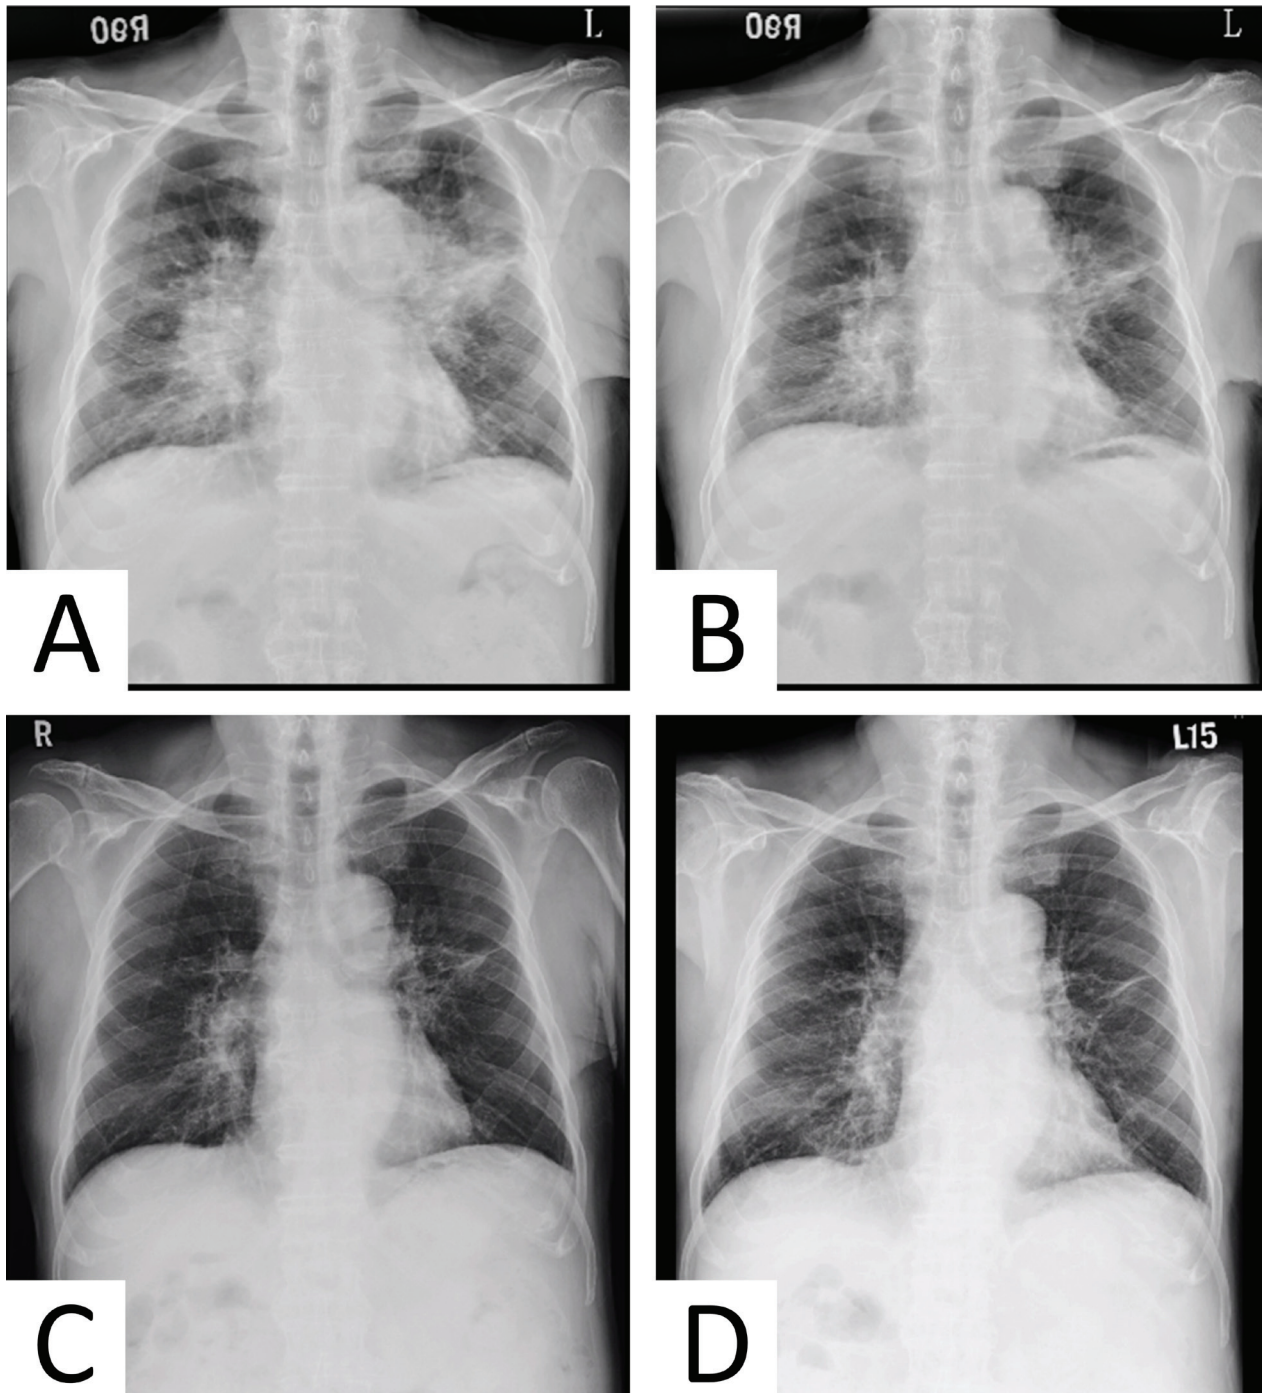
Serial chest radiographs of this 78-year-old man showed a rapid response to corticosteroid therapy, with long-lasting effects. (A) On day 1, a chest radiograph just prior to the corticosteroid therapy showed patchy consolidations with a central distribution in the bilateral hilar area. (B) After completion of a 7-day course of intravenous methylprednisolone (60 mg/day), the chest radiograph showed rapid improvement. (C) Three weeks after initiation of corticosteroid therapy, the chest radiograph revealed near complete resolution of bilateral central pulmonary consolidations. (D) The one-year follow-up chest radiograph showed stable results with low-dose oral prednisolone (5 mg/day) treatment.
